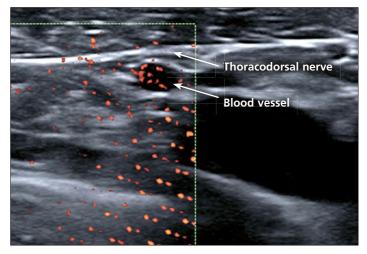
The color Doppler image alerts to the risk of puncture and confirms the position of the nerve.
